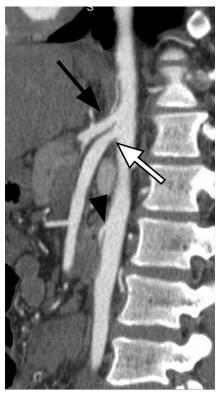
Sagittal CTA image of the abdominal aorta well shows the origins of the CA (*black arrow*), SMA (*white arrow*), and IMA (*black arrowhead*).
